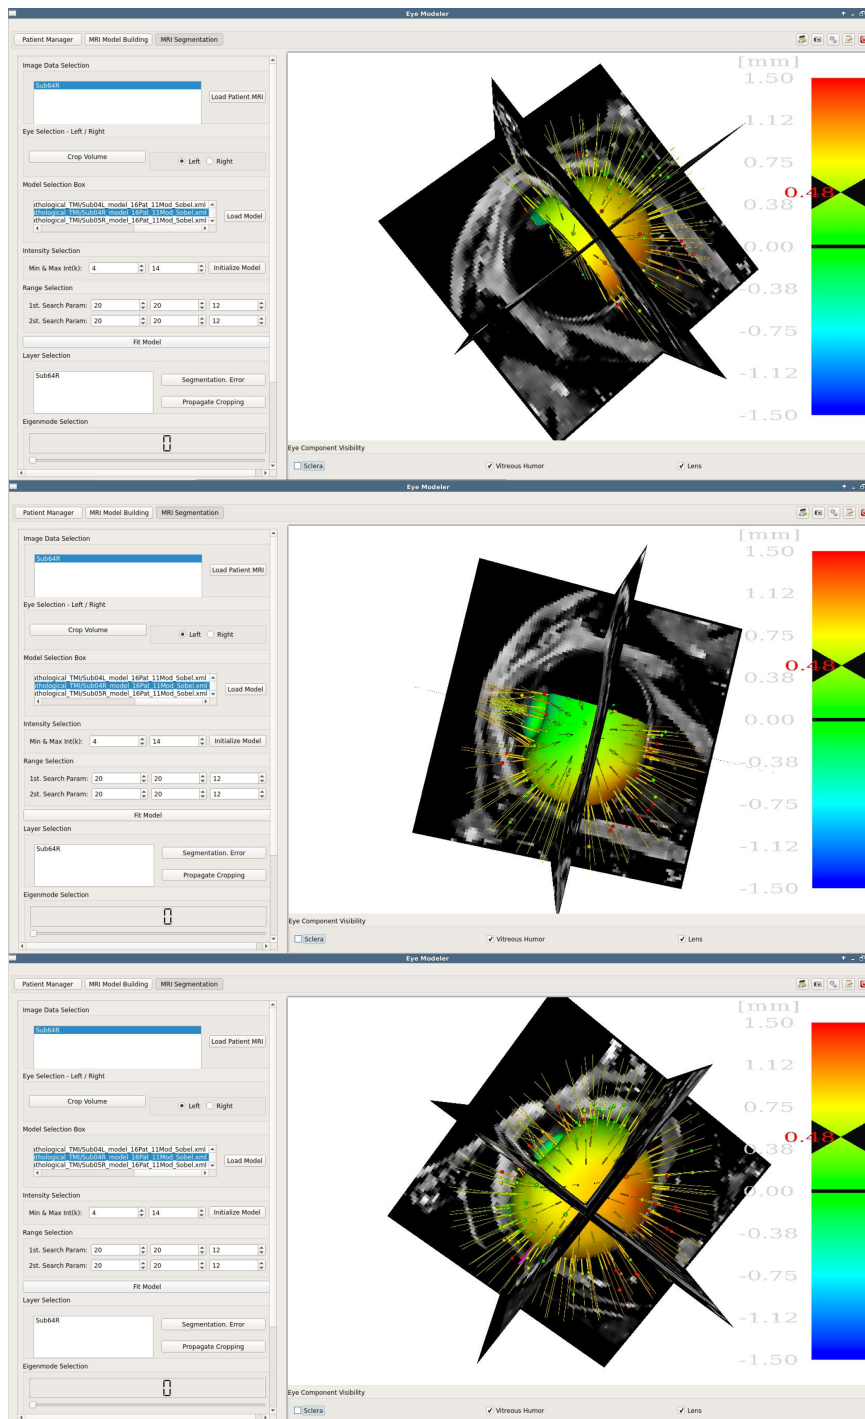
EyeModeler : EyeModeler navigation systems allows clinicians to explore different segmentation methods and to perform automatic segmentation of healthy and pathological eyes on the MRI.
